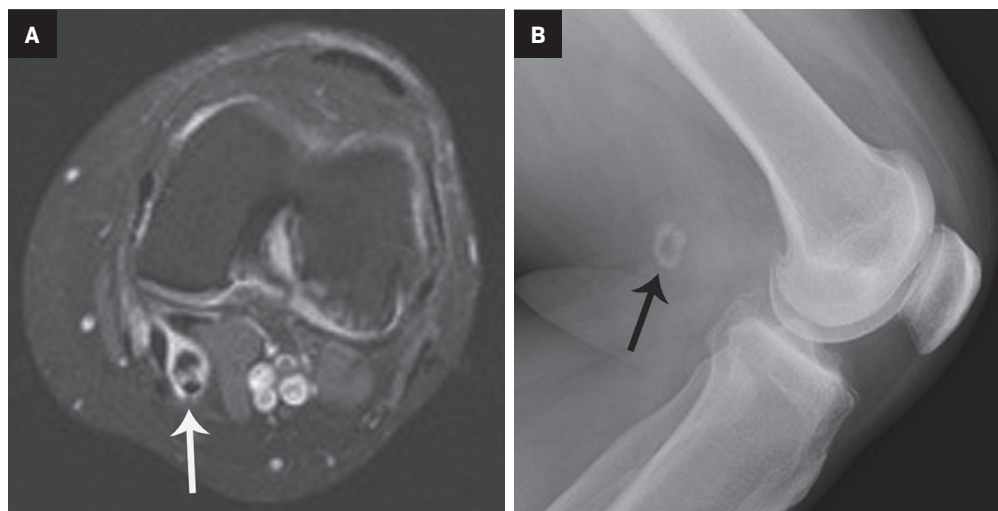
Baker cyst osteochondral body. (A) Lateral radiograph shows an osteochondral body (arrow) with peripheral mineralization in the soft tissues of the posterior knee. (B) Axial proton density fat saturated MR image shows the osteochondral body located inside of a Baker cyst.
